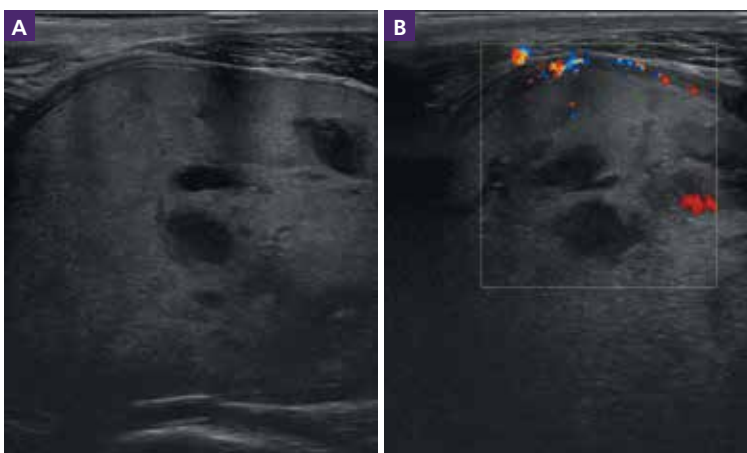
(A) Transverse B-mode ultrasound image of an enlarged and heterogeneous right thyroid gland, representing a thyroid adenoma. (B) The colour flow Doppler is applied to determine regional blood vessel presence.
